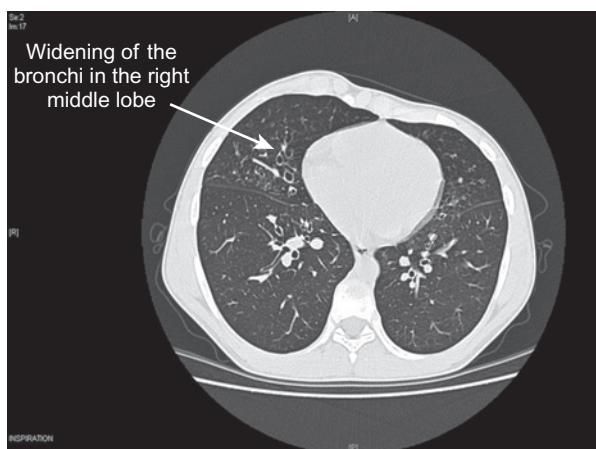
High resolution CT scan of the chest demonstrating bronchiectasis.
